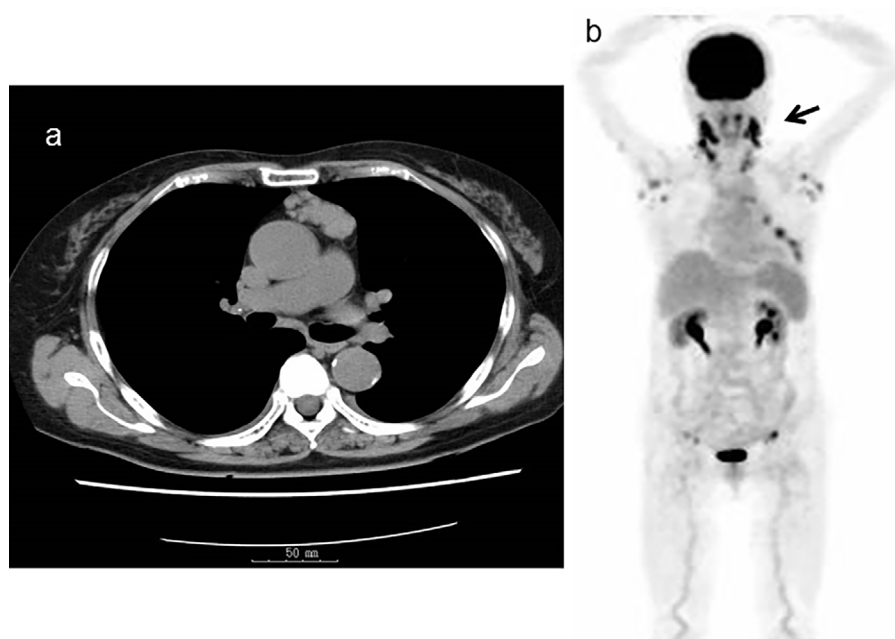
a: A computed tomography scan showing an anterior mediastinal tumor. b: A positron emission tomography scan revealing an abnormal fluorodeoxyglucose uptake in the lymph nodes of the neck, supraclavicular region, pulmonary hilum, and inguinal region [maximum standardized uptake value (SUV), 7.1], spleen (SUV, 3.4), left lung (SUV, 5.6), and mediastinal tumor (SUV, 3.0).
